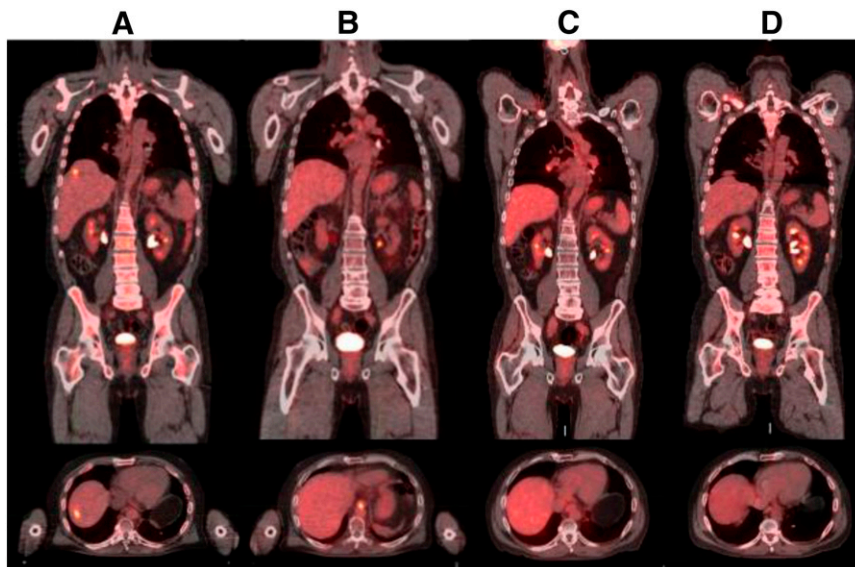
Response to crizotinib in a patient with *MET*-amplified gastric cancer identified by prospective comprehensive genomic profiling. (A): Precrizotinib FDG-avid hepatic metastasis. (B–D): Ongoing response up to 5 months after crizotinib initiation.
